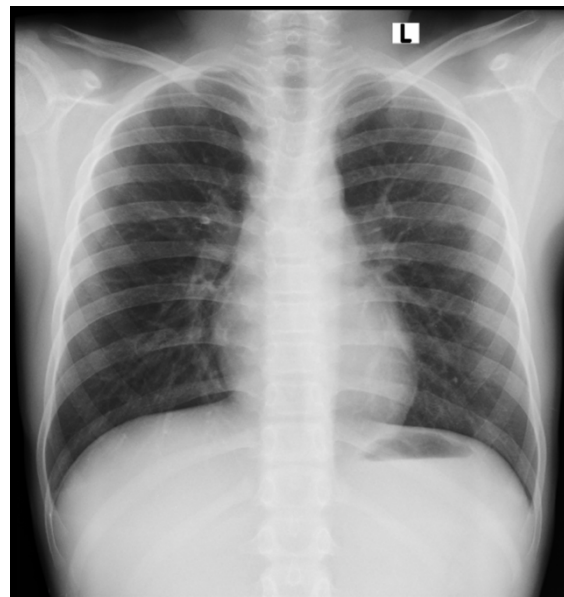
Chest X-ray posterioranterior view revealed no opacities or consolidation observed in both lungs, heart size and structure are within normal limits.
